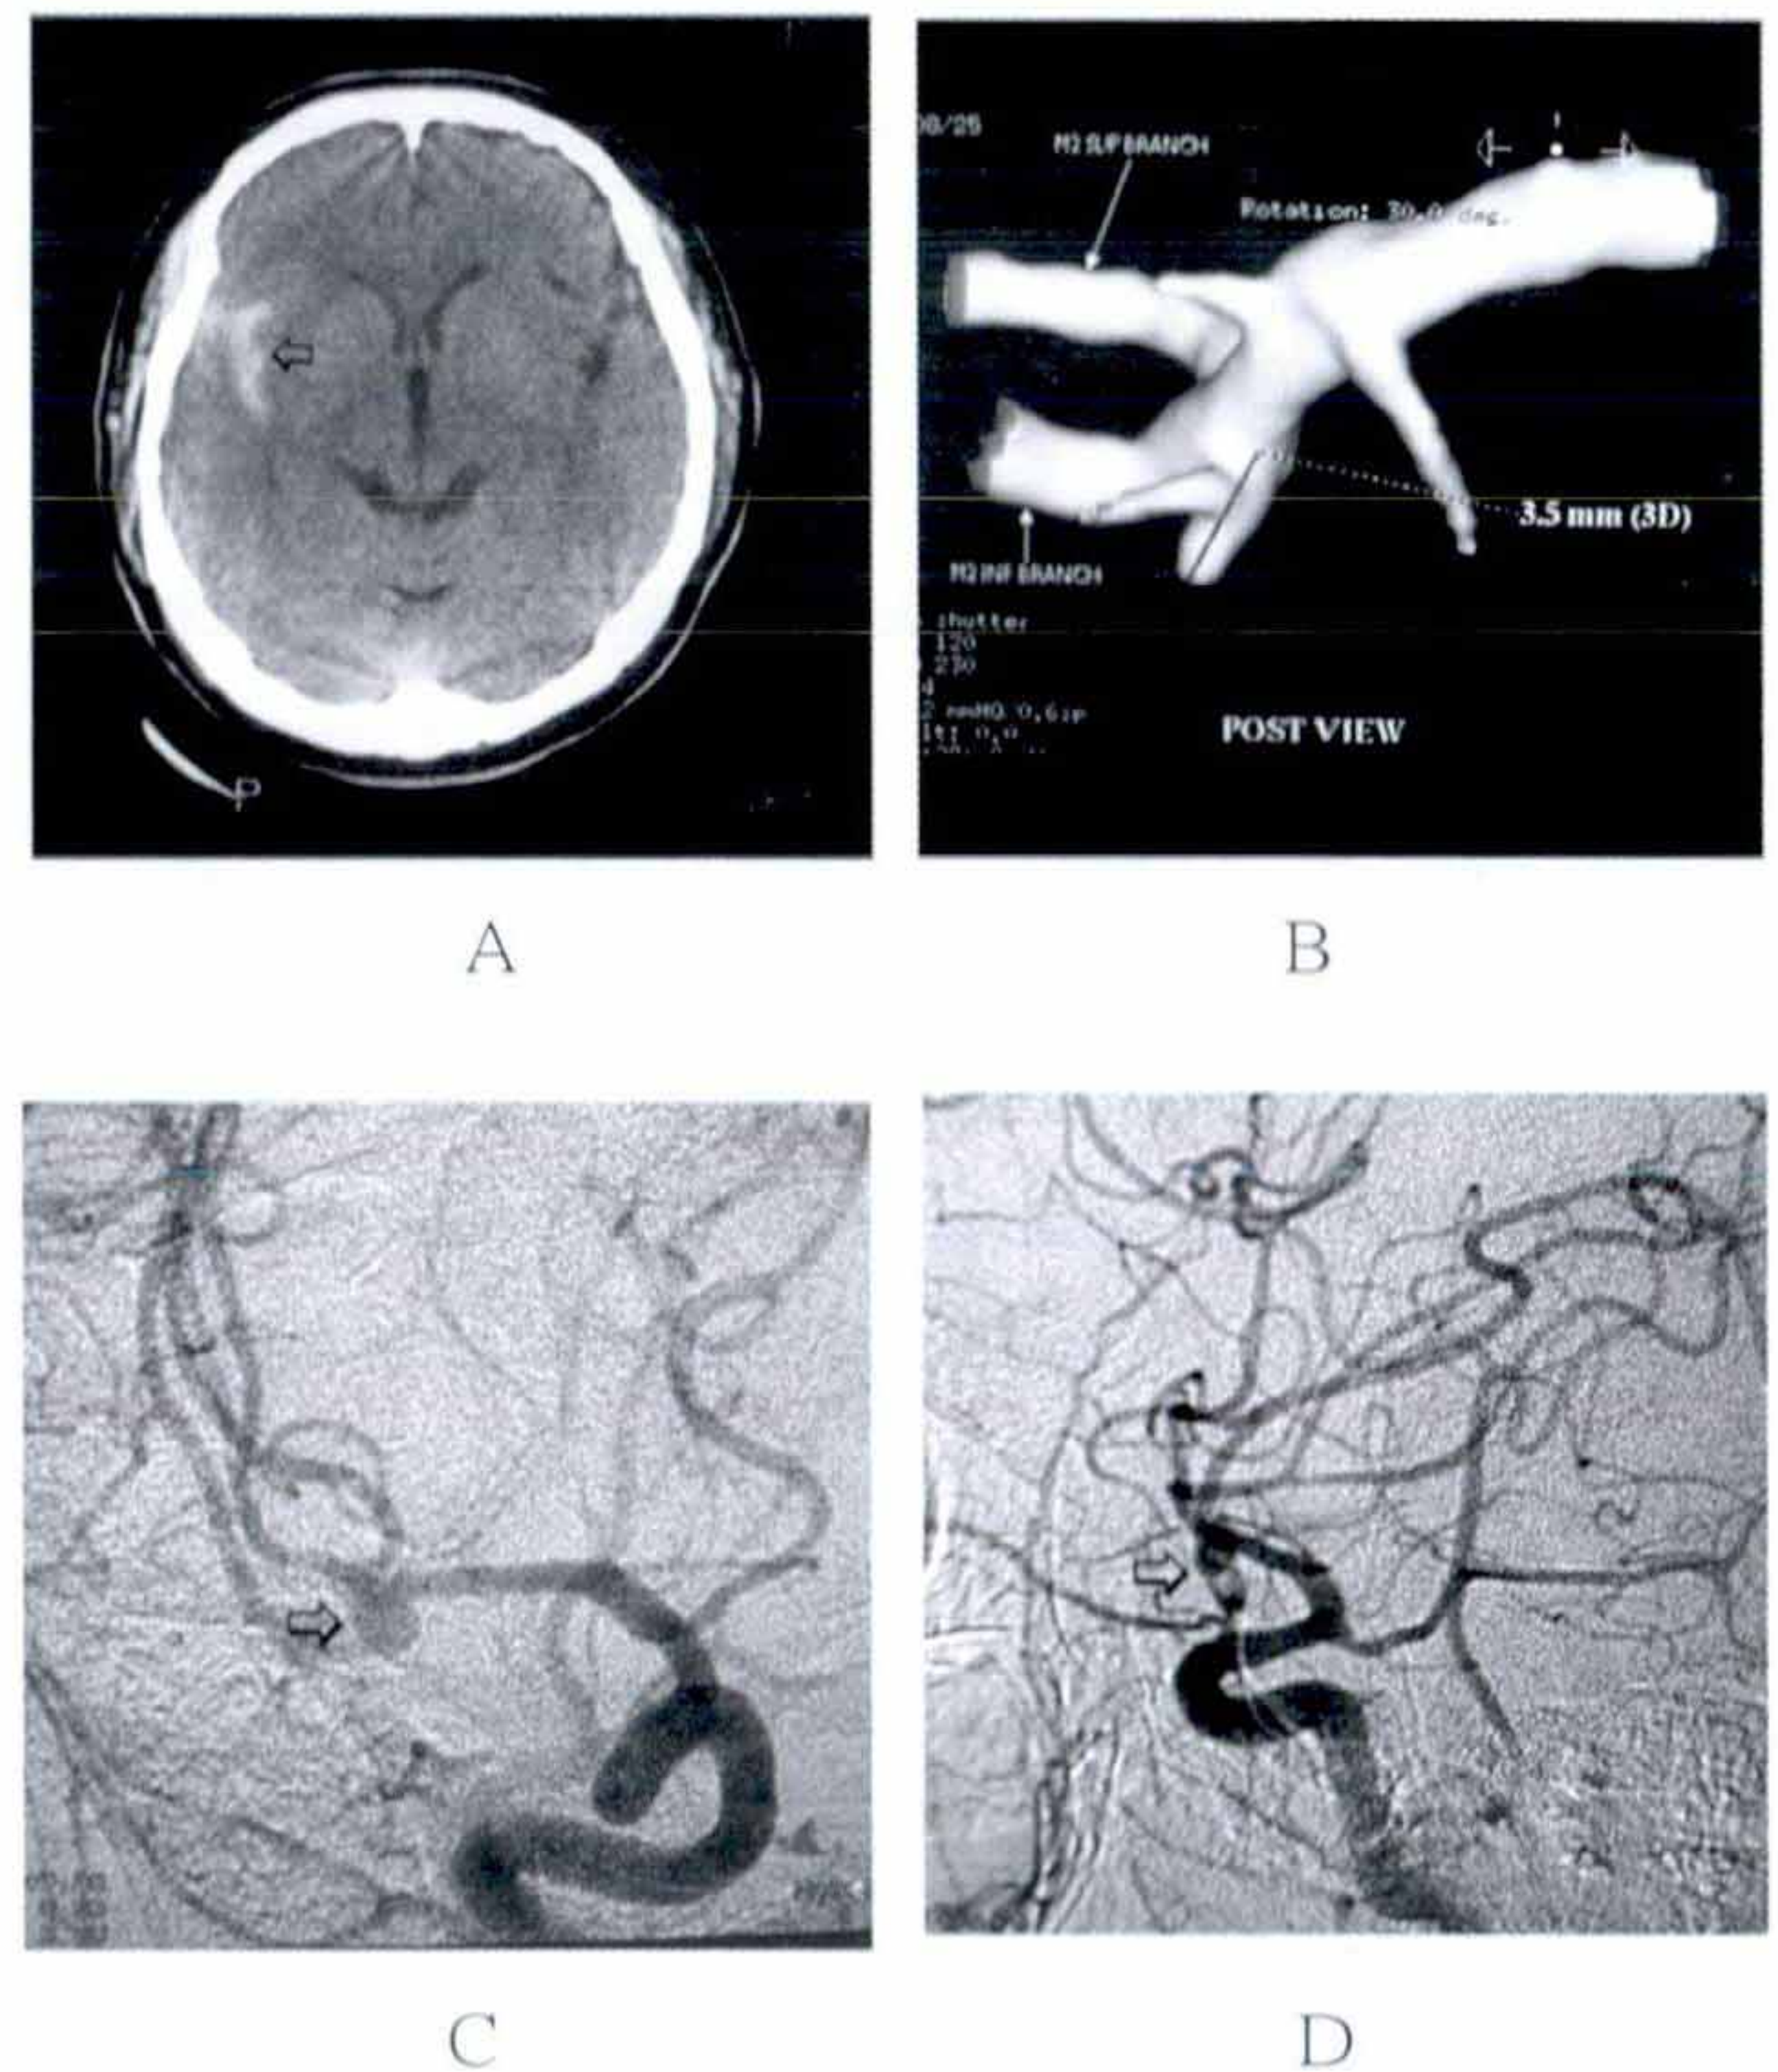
These 4 films show preoperative result he was checked. A : CT scan shows high density in right sylvian fissure. (FG: II) B : 3-D CT scan shows in MCA bifurcation there is a posterior, inferior aneurysm. C & D : Angiography reveals an aneurysm on MCA bifurcation, posterior and inferior direction. The black arrow indicates the site and direction of the aneurysm.
